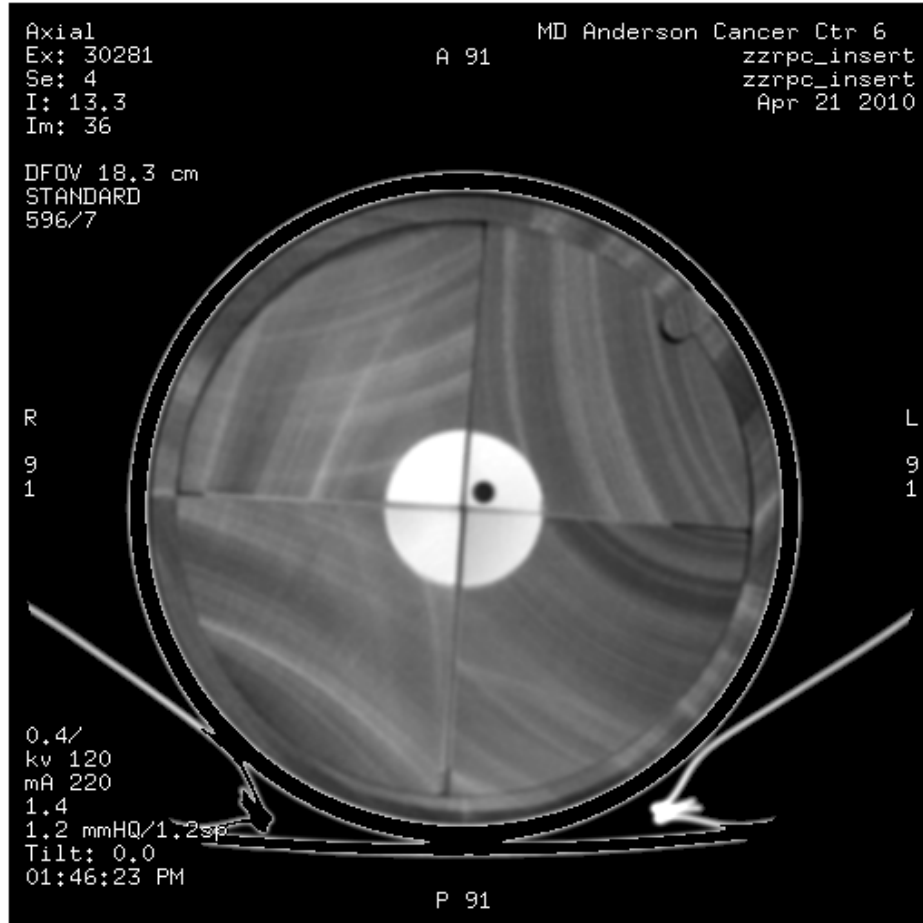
High resolution CT scan of imaging/dosimetry insert
